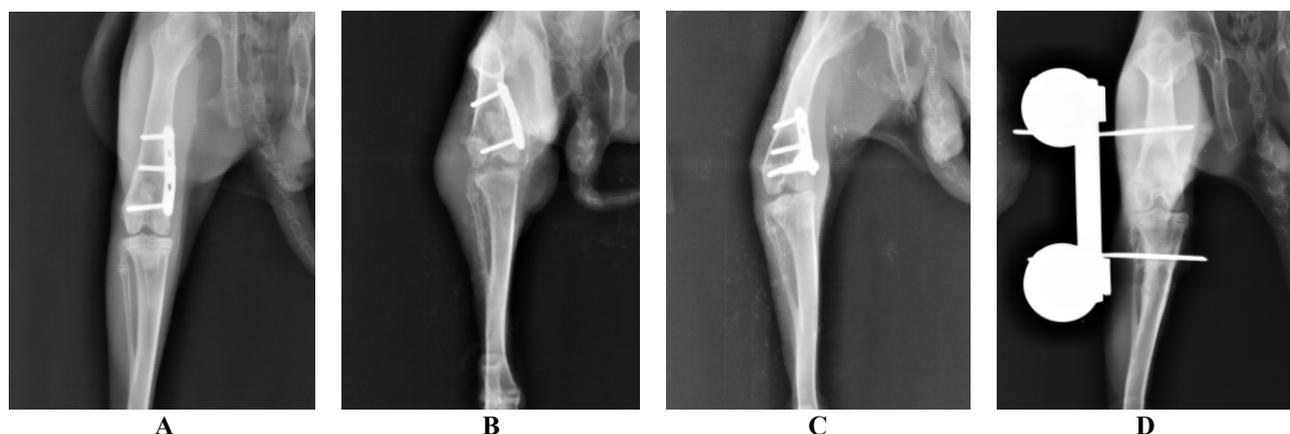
Radiographic representation 4 weeks post knee joint fracture surgery.
